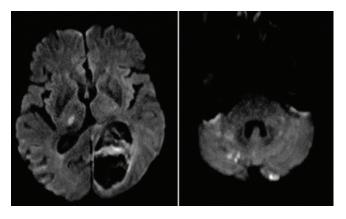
Diffusion-weighted magnetic resonance image of brain on day 3 of admission.
